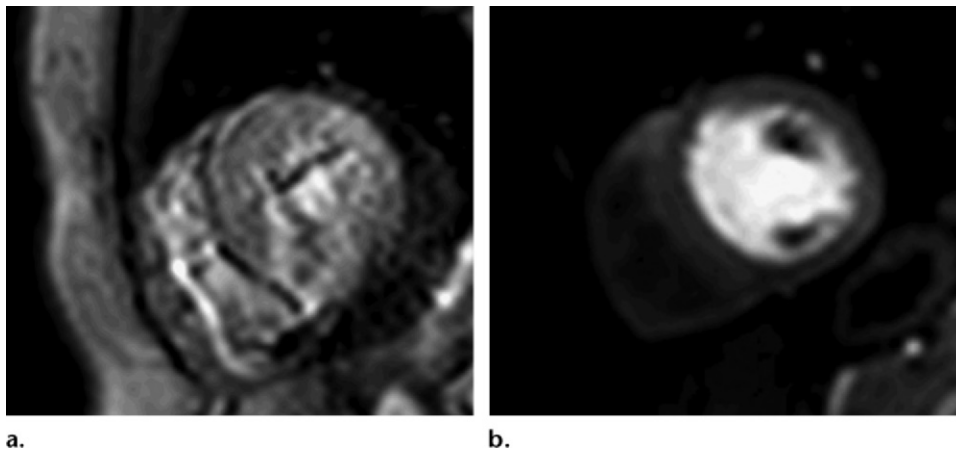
Stress perfusion imaging at 1.5 T and 3 T. (a) Stress perfusion MR image at 1.5 T shows suboptimal spatial resolution and SNR. (b) Stress perfusion MR image at 3 T shows much higher SNR and spatial resolution, with no evidence of any artifact.
